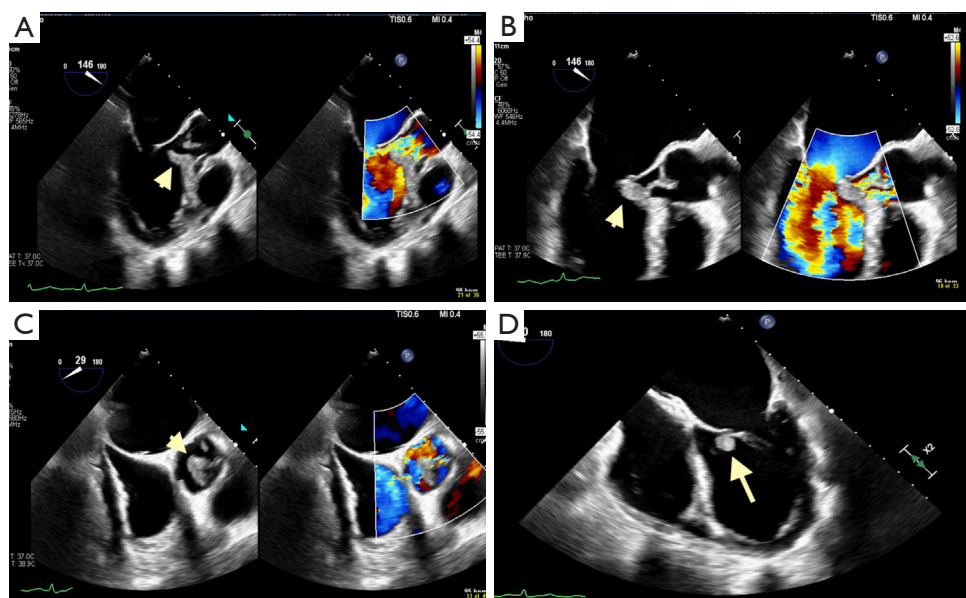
Pre-operative TEE images on January 20, 2020. (A) Mid-esophageal long axis view showing AV vegetation measuring 21×9 mm (arrowhead) attached to the RCC and hitting the AMVL in diastole. There is a severe jet of AV regurgitation. (B) Mid-esophageal long axis view showing the aortic valve vegetation (arrowhead) touching the AMVL. (C) Mid-esophageal short axis view of the AV vegetation (arrowhead). (D) Mid-esophageal 4 chamber view showing a small vegetation 7×4 mm (arrow) on the AMVL. TEE, transesophageal echocardiogram; AV, aortic valve; RCC, right coronary cusp; AMVL, anterior mitral leaflet.
